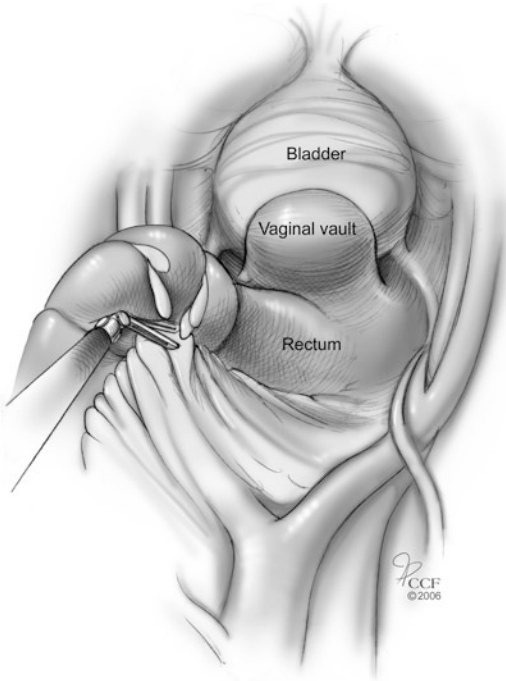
Retraction of the sigmoid colon with a CT-X needle through an epiploic appendage. The needle can be placed through the abdominal wall and clamped at the skin level to retract the sigmoid colon allowing exposure of the sacral promontory
